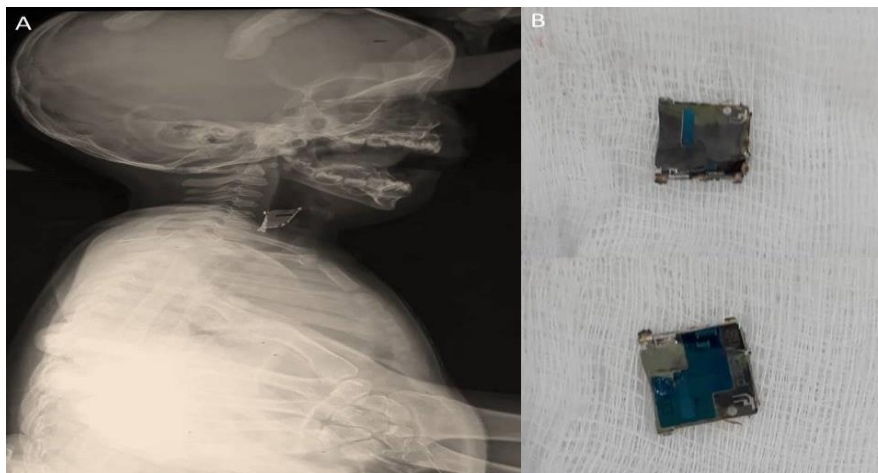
A 9-month-old boy presented with a hypopharyngeal Foreign body. A. Plain X-ray lateral view showed metallic Foreign body at the level of C4-6 vertebrae. B. The extracted Foreign body (Sim Card slotter of an old fashion mobile phone).
